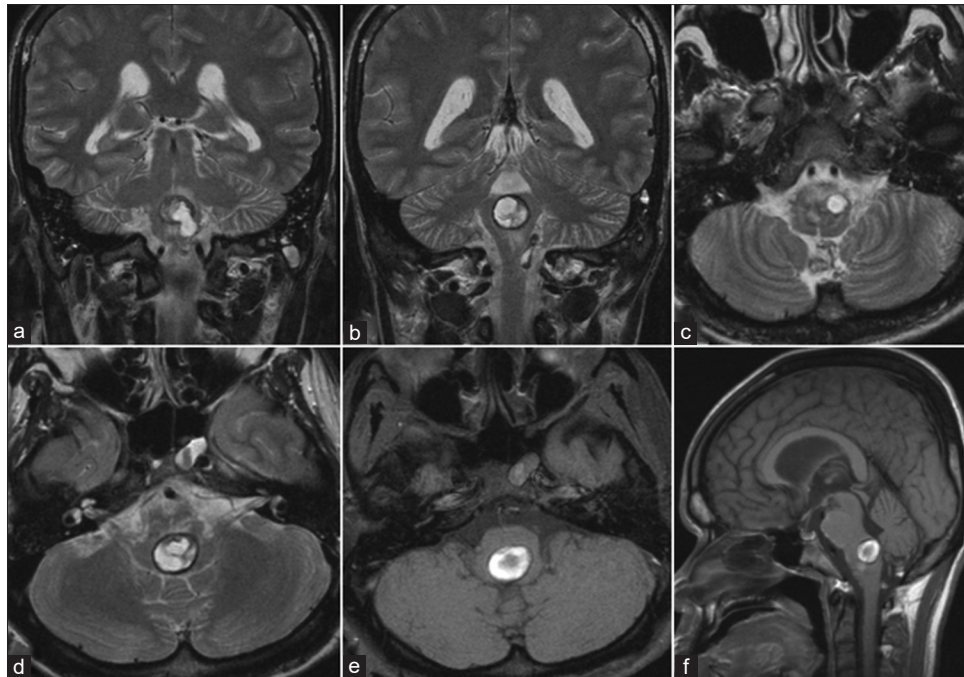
Magnetic resonance imaging of the brain obtained 1 week after endovascular treatment. Coronal (a and b), axial (c and d) T2-weighted, axial (e), and sagittal (f) T1-weighted magnetic resonance imaging reveal a large round mixed central isointense and peripheral hypointense mass with hyperintensity in a venous aneurysm, probably representing a thrombosed venous aneurysm with resolving hematoma. There was disappearance of previously seen venous congestion of the medulla and multiple dilated flow-voids surrounding the medulla
